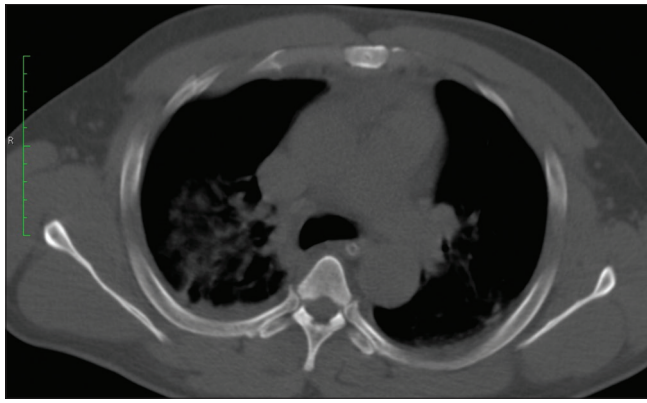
Chest computed tomography scan showing lung contusion
